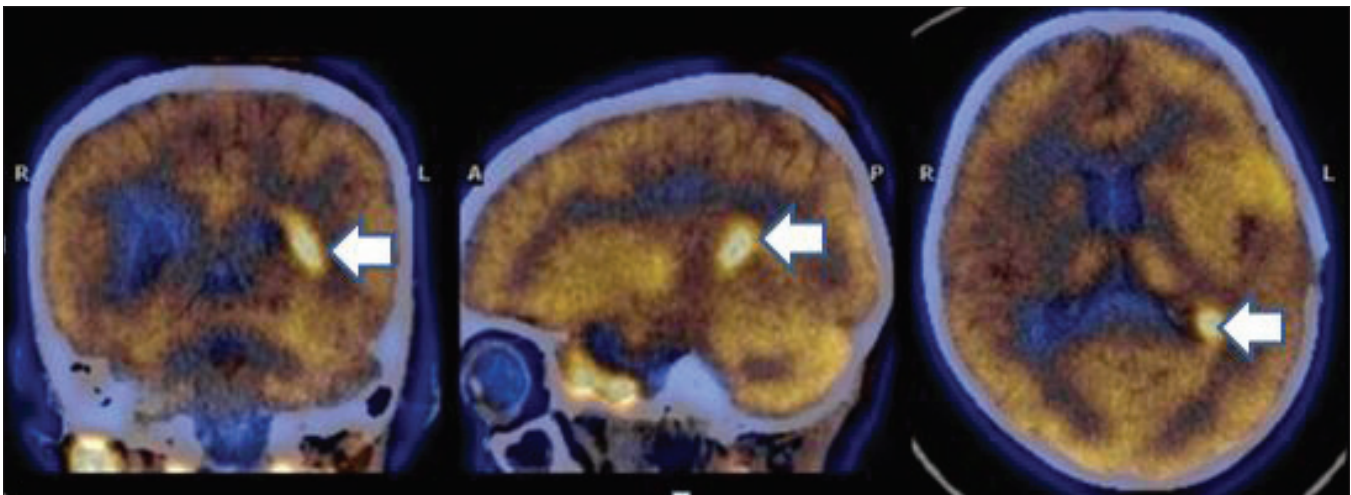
Coronal, Saggital and Transaxial fused C-11 Methionine PET/CT images
